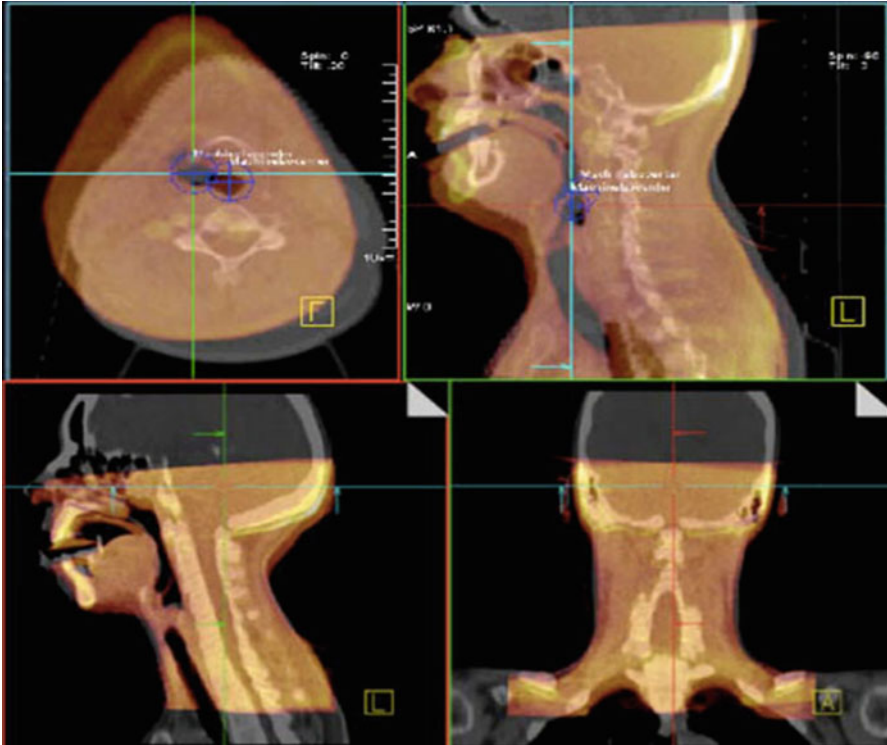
Image registration of a reconstructed MVCBCT image to the planning CT (Courtesy of Jean Pouliot, PhD)
